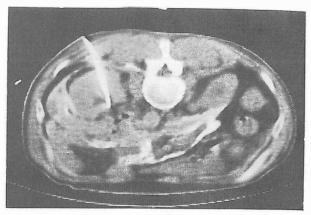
Bilateral obstructive nonfunctioning kidneys in a patient with rectal carcinoma. Prone CT-scan obtained for demonstrating anatomic detail and localization of puncture site. (A) Reveals slight dilatation of the collecting system on the left side. Percutaneous
